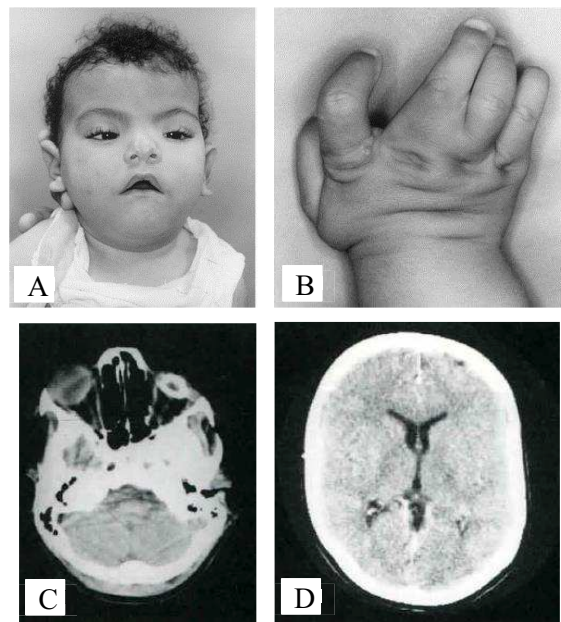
Representative pictures of the hallmarks of AFFND1. (A-B) A Brazilian patient showing wide forehead, broad-notched nasal tip, bilateral cleft lip and palate, camptodactyly. (C-D) Computed tomography (CT scan of one Brazilian patient showing normal cerebral parenchyma, microphthalmia with dense calcification of eye structures at left. Adapted from Richieri-Costa et al., 1992 and Guion-Almeida et al., 2003.
